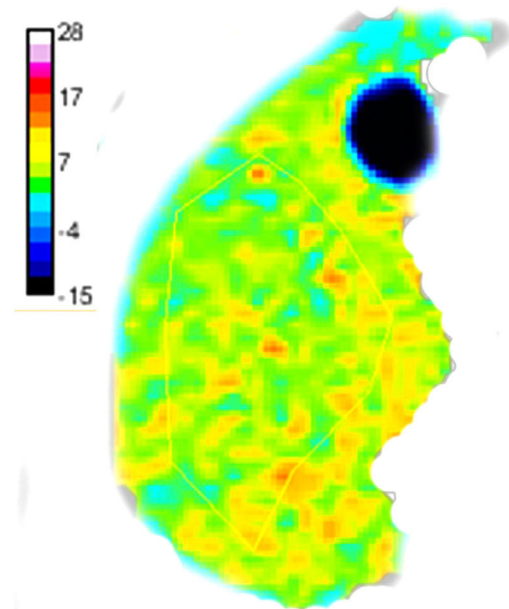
Examples of placement of region of interest in the liver parenchyma on DWI-based virtual shear modulus (μ_{Diff}).
